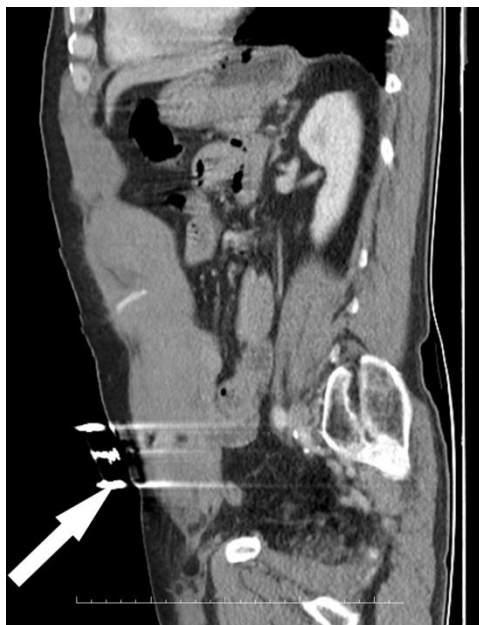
Sagittal CT image shows the extension of RSM to the level below the umbilicus (arrow).
